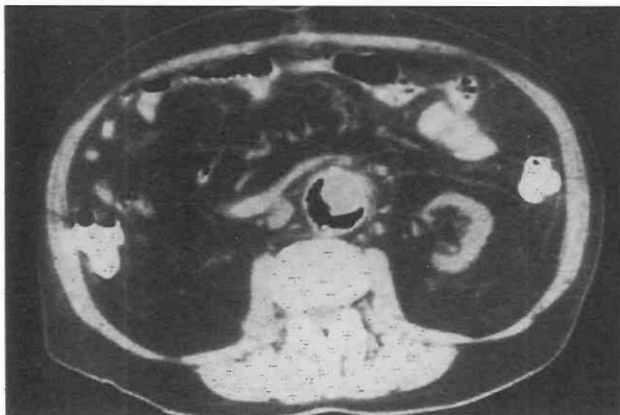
Infected aortic graft. Air has accumulated within the space between the graft and the surrounding native aorta on this unenhanced CT scan. The patient had undergone endoneurorrhaphy.
